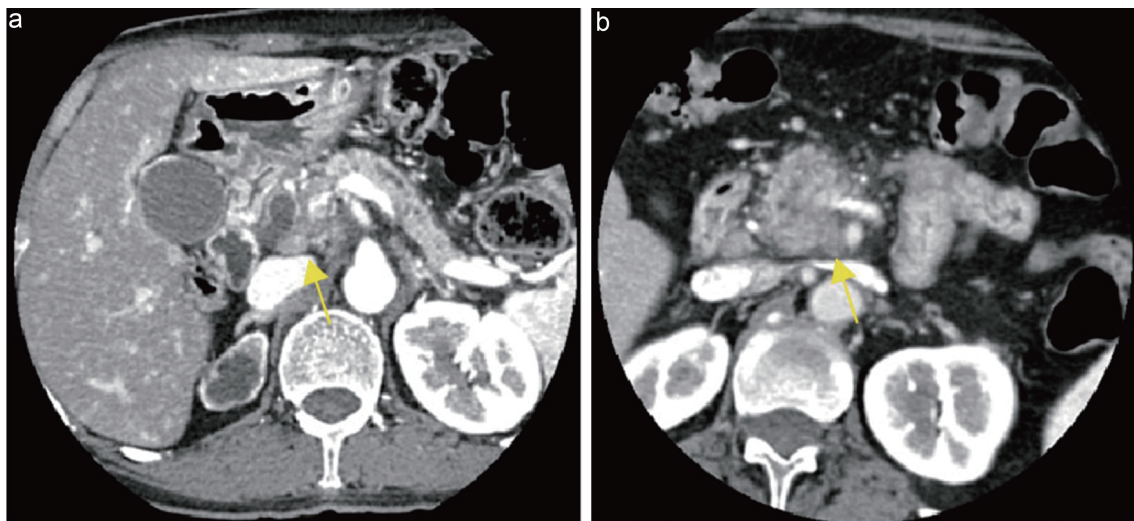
Imaging evaluation of lymph nodes in pancreatic cancer. (a) Axial arterial late-phase CT image showing a round, well-defined, homogeneously enhancing lymph node (short-axis ~ 0.8 cm) inferior to the pancreatic head (yellow arrow); pathology was negative. (b) Axial arterial late-phase CT image showing a round lymph node with slightly low attenuation (short-axis ~ 1.2 cm) inferior to the pancreatic head (yellow arrow); pathology was positive.
